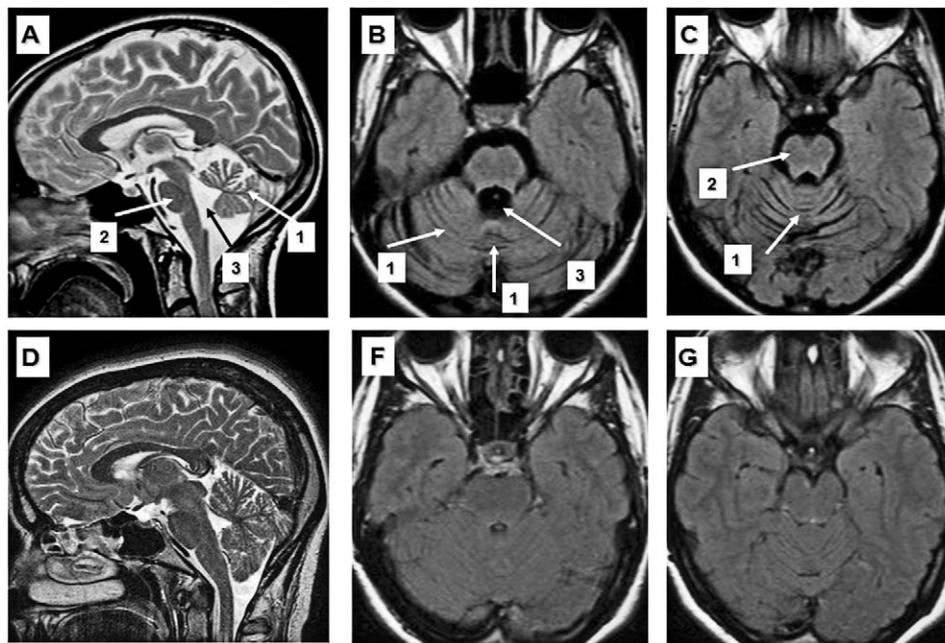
Sagittal (A, D) T2-weighted and axial (B, C, E, F) T2-weighted/flair MRI of a patient with SCA-3 (A, B, C), and an aged matched control (D, E, F). Arrows indicate cerebellar (1) and brainstem (2) atrophy with marked fourth ventricle (3) enlargement.
